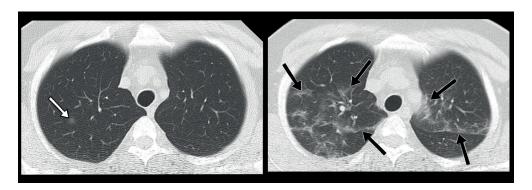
A 46-year-old male patient. Initial chest CT demonstrates a nodule of ground-glass density in the right lung (white arrow). Follow-up chest CT demonstrates bilateral wide-spread ground-glass densities (black arrows).
